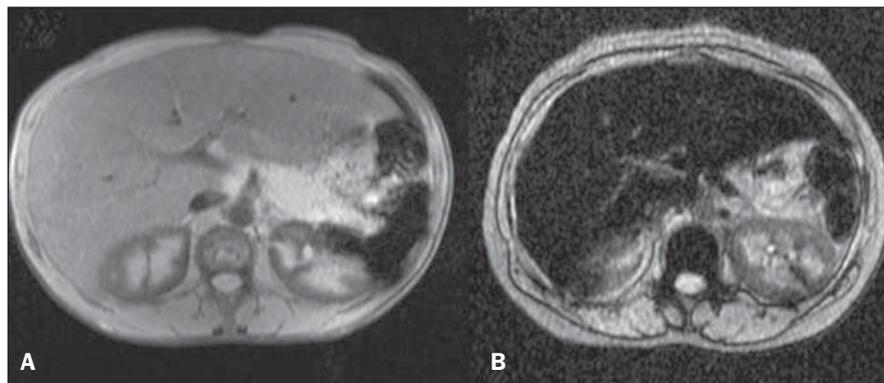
Abdominal MRI T2-weighted sequence* (TE = 13 ms). A: Patient with EHIC of $20.7 \mu\text{mol/g}$. B: Patient with EHIC of $262.2 \mu\text{mol/g}$. The noticeable difference in signal intensity between both livers is observed.
